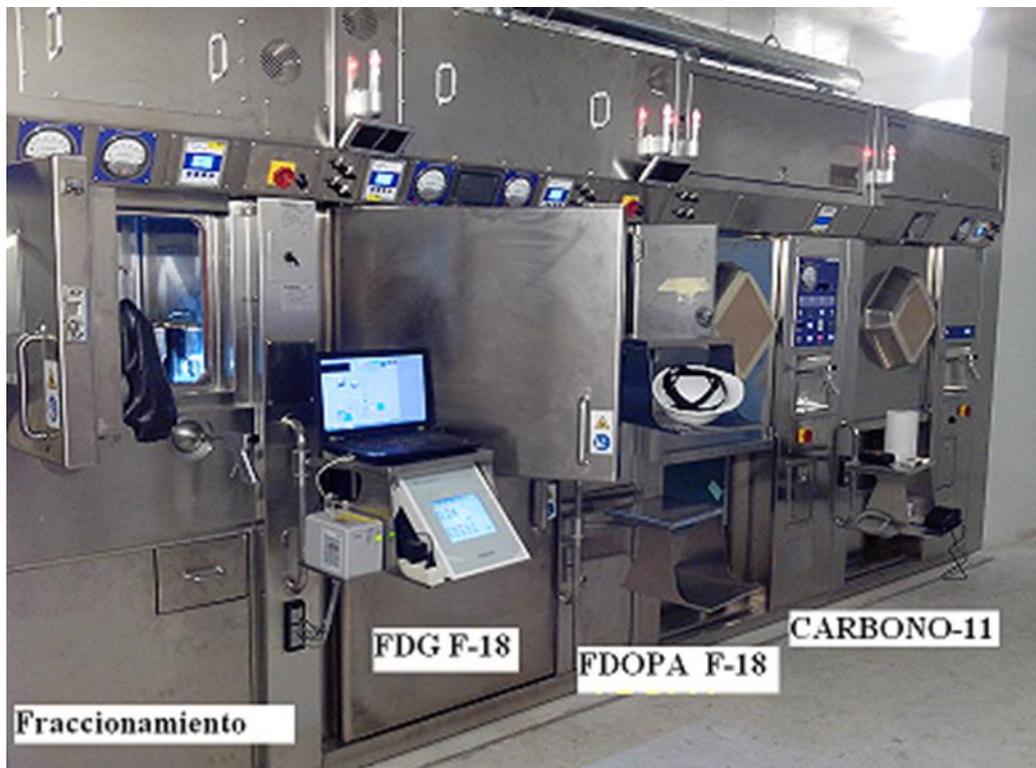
Cell for ^{18}F -FDG Synthesis Modules
